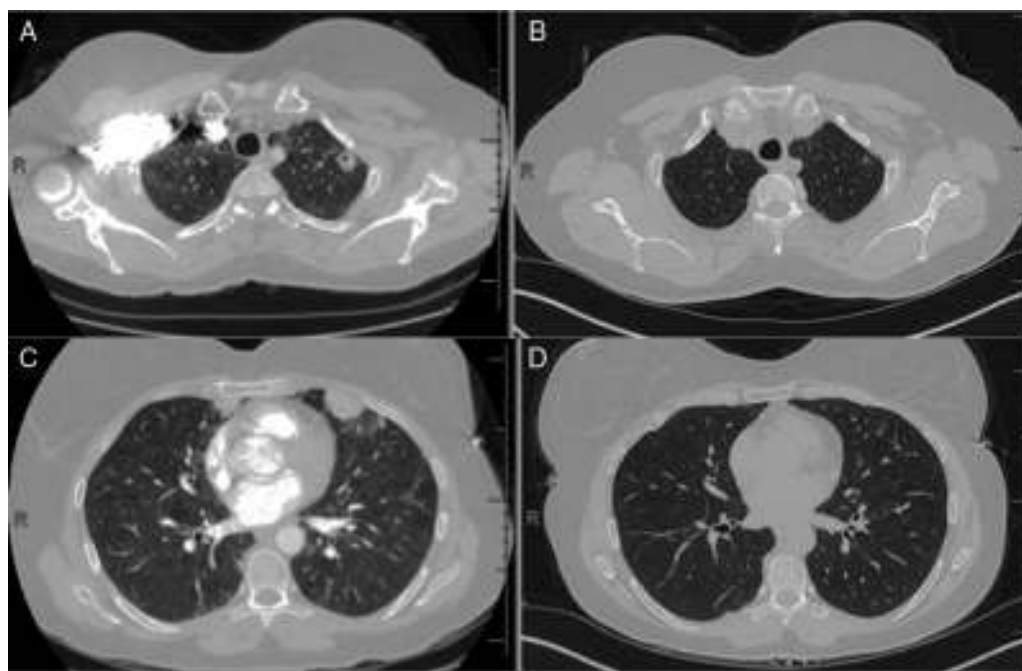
CT of chest (A), initial CT demonstrating left upper lobe nodule with cavitation (B), nine month follow-up CT with resolution of left upper lobe nodule, (C) initial CT demonstrating peripheral nodule in the lingual and (D) nine month follow-up CT with resolution of peripheral nodule in the lingual.
